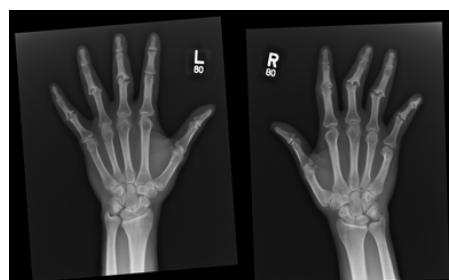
X-ray images of the bilateral hands demonstrating erosive changes of the PIPs bilaterally.
